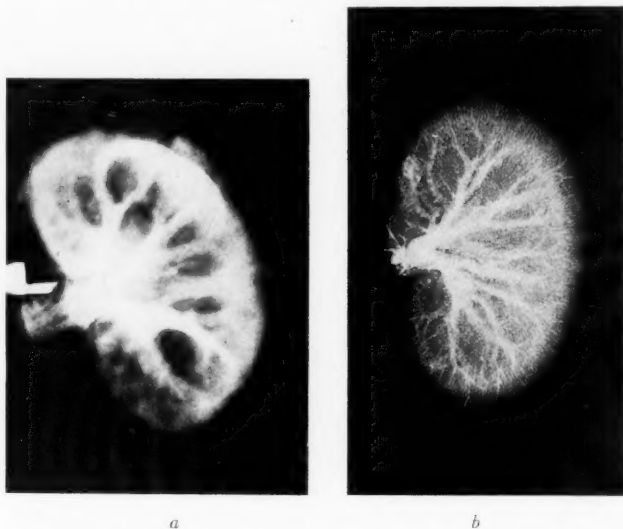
Radiograph of an injection of the arterial circulation of the kidney:
